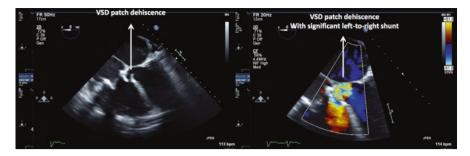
VSD patch dehiscence as pictured with transesophageal echocardiography without (left panel) and with colour Doppler (right panel). *VSD* ventricular septal defect
